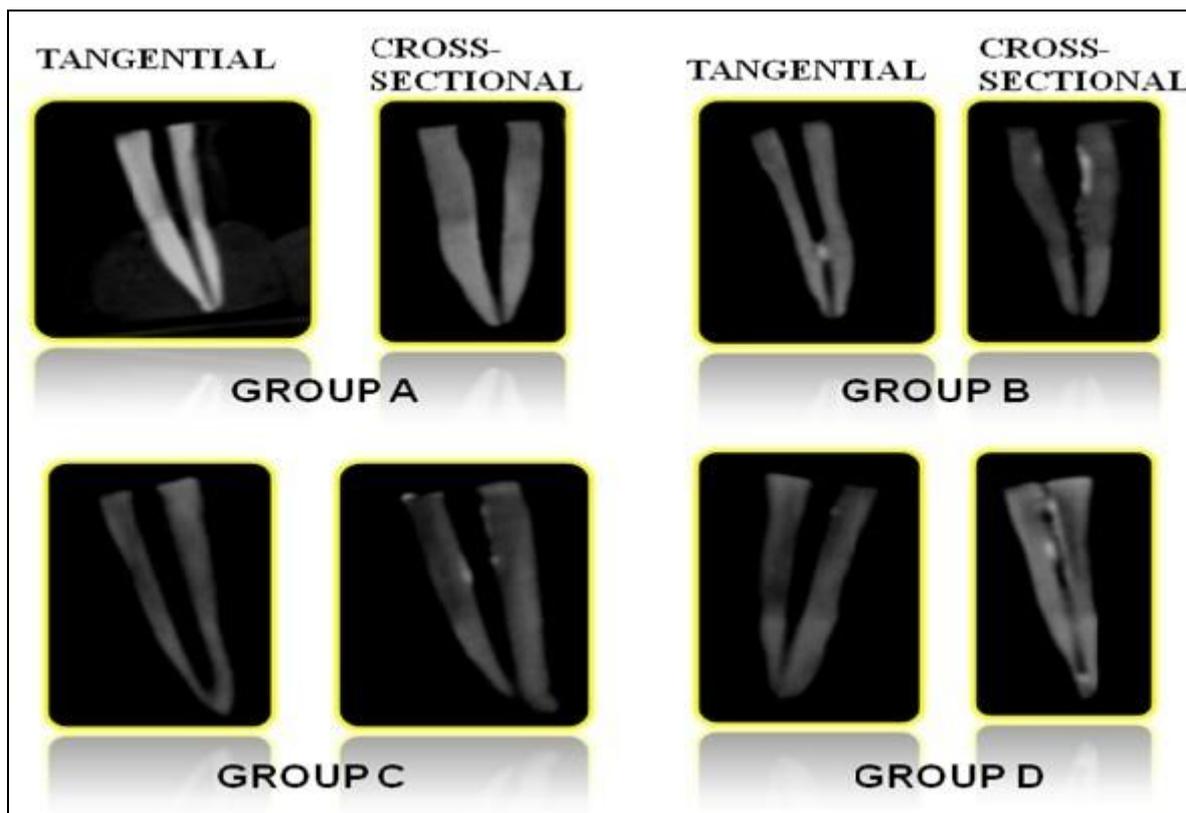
Tangential and Cross-sectional CBCT image after Retreatment.
